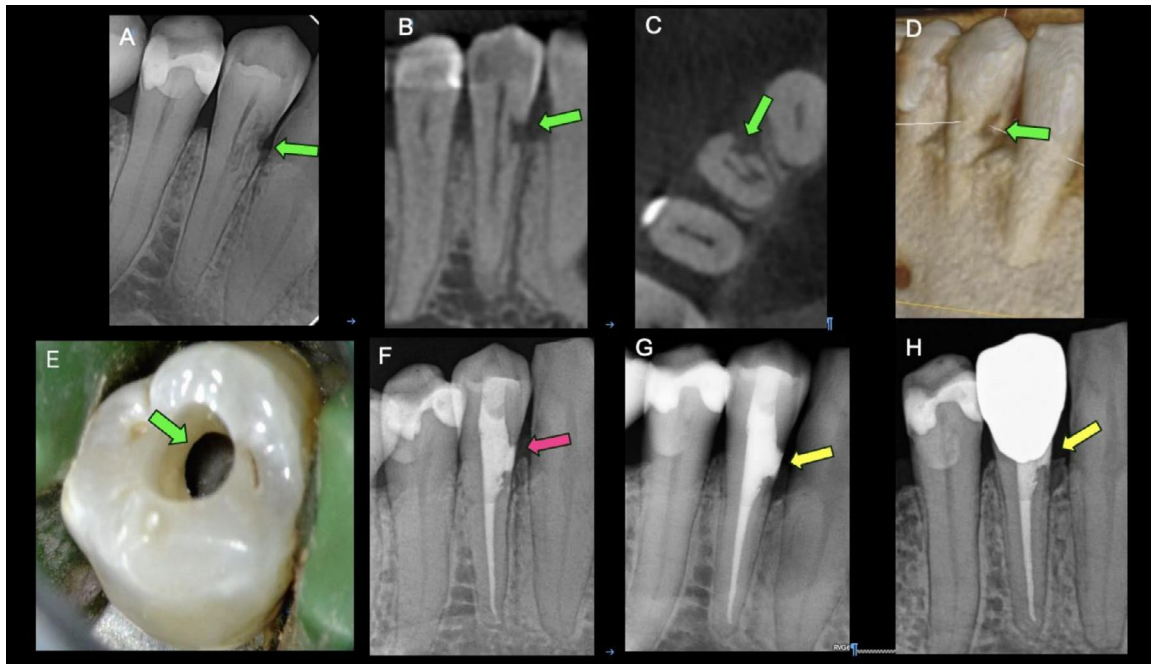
Treatment option 3, Internal repair & endodontic treatment. ECR associated with lower right first premolar (44). (A) pre-operative periapical radiograph, (B, C) pre-operative axial and sagittal CBCT image, (D) 3D rendered image, (E) access cavity extended to encompass the ECR lesions, (F) post-operative periapical radiograph, (G) 1-year follow-up, (H) 2-year follow-up periapical radiographs.
